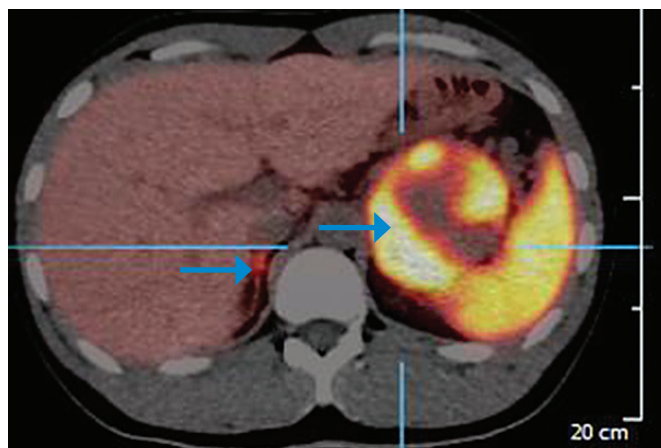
Axial view of the ⁶⁸Gallium-DOTATATE PET-CT showed an avid left adrenal mass (SUVmax 45.0) with necrotic centre whereas the right adrenal nodule was still within the physiological uptake (SUVmax 19.6) (blue arrows).
